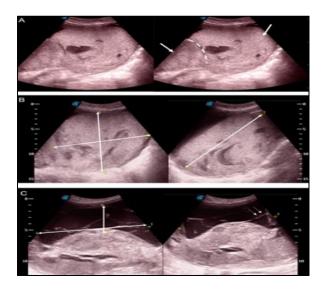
(A) Ultrasound at 20 weeks demonstrating a normal placenta tissue on the left of demarcation and the MST on the right. (B) Ultrasound at 23 weeks of gestation showing a hyperechoic placental mass (Vol=1100mls) with anechoic cystic spaces. (C) Same placenta mass at 27 weeks. Smaller in size (Vol=256mls) with an anechoic layer that has reticulate sonolucent areas.
